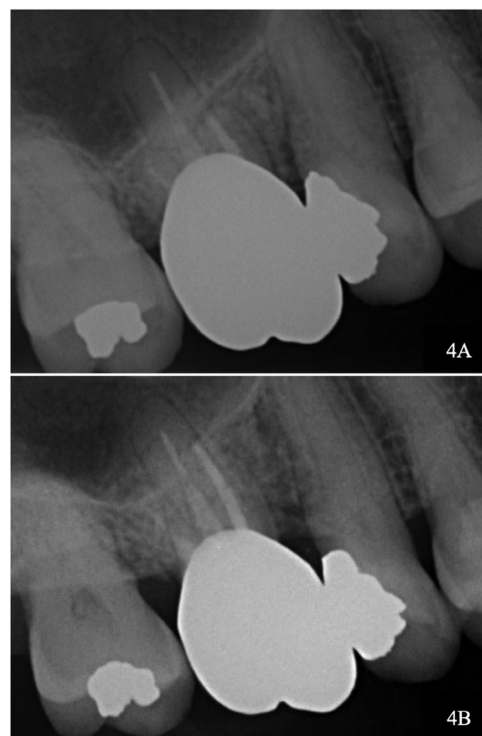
Follow-up periapical radiographs. (4A) At 1-year; (4B) At 1.5-year.
